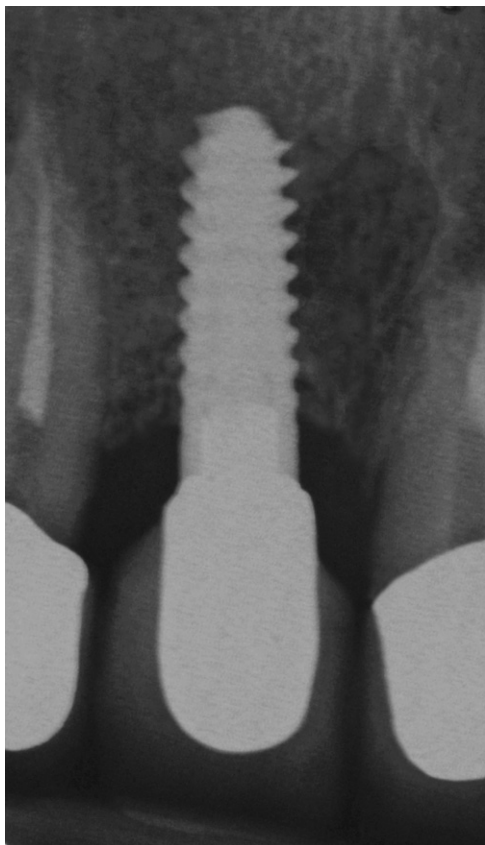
Radiographic examination of bone tissue, after 3-year follow-up.
